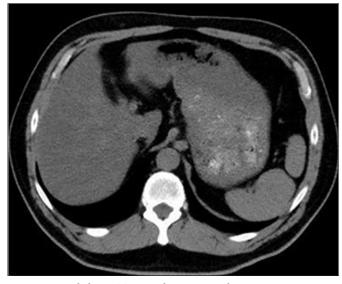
Axial chest CT image demonstrates hepatosteatosis (mediastinal window). Mean liver attenuation is 13 HU and mean splenic attenuation is 46 HU
